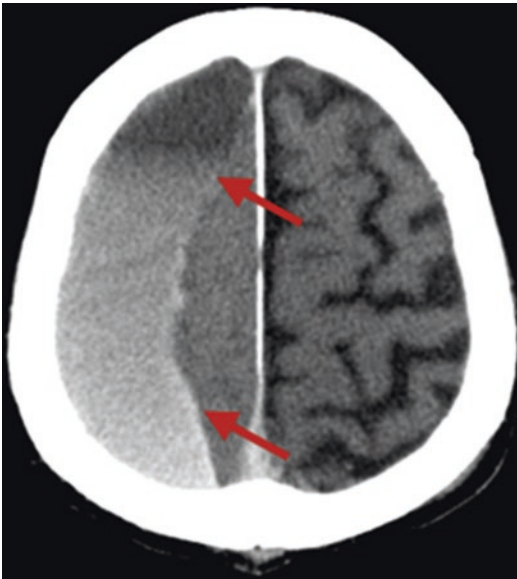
Axial brain computed tomography image of a typical chronic subdural hematoma. Fluid-fluid level is formed inside the hematoma, suggesting hemorrhagic, less coagulated fluid in the cavity. Note the high-density linear lesion on the surface of the brain, suggesting that the membrane formed after injury (arrows)
